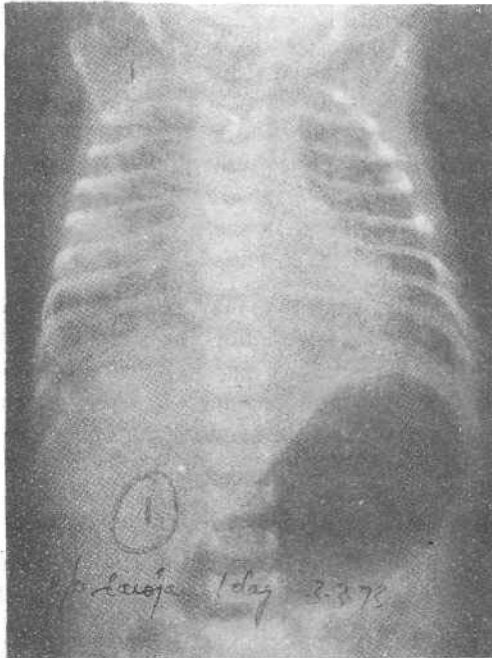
Chest X-ray taken at 3 hours of age showing bilateral diffuse opacities.
